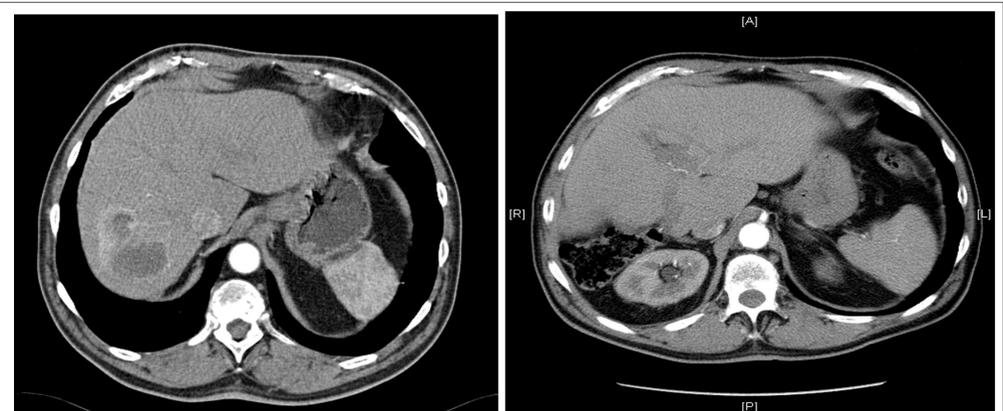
Left image Arterialised CT image, demonstrating NET in right lobe liver. Right image post operative image demonstrating resection of liver metastases without evidence of further disease.
